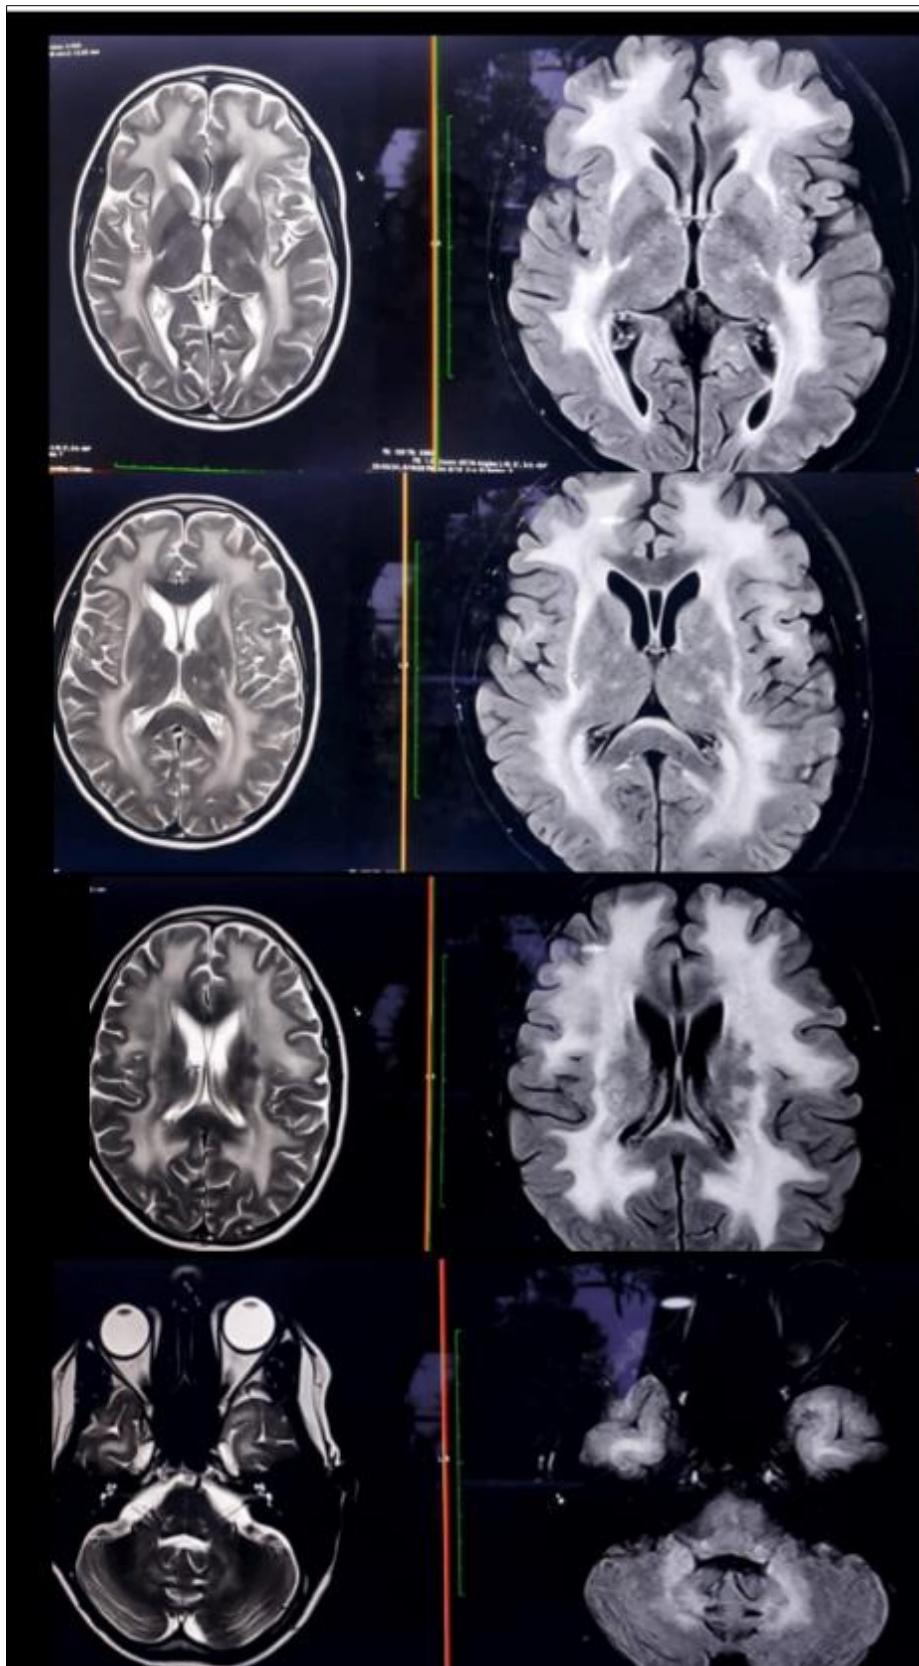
Axial T2-weighted Brain MRI image(left) and Axial FLAIR Brain MRI image(right): showing diffuse leukoencephalopathy
